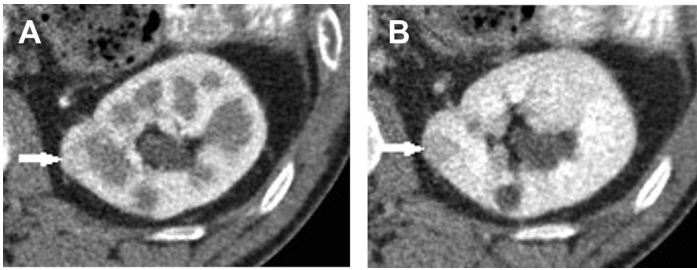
(A) Corticomedullary phase and (B) nephrographic phase axial contrast-enhanced CT images of the left kidney show improved detectability of 1.2-cm ccRCC (arrows) when there is greater enhancement difference between the tumor and renal cortex in the nephrographic phase.
